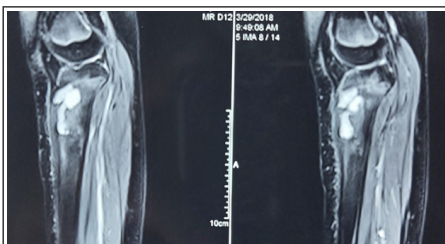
Magnetic resonance imaging of the right knee joint (T2-weighted image) showing a well-defined multiple cystic lesion arising from the anterior aspect of proximal metaphysis of the tibia.
